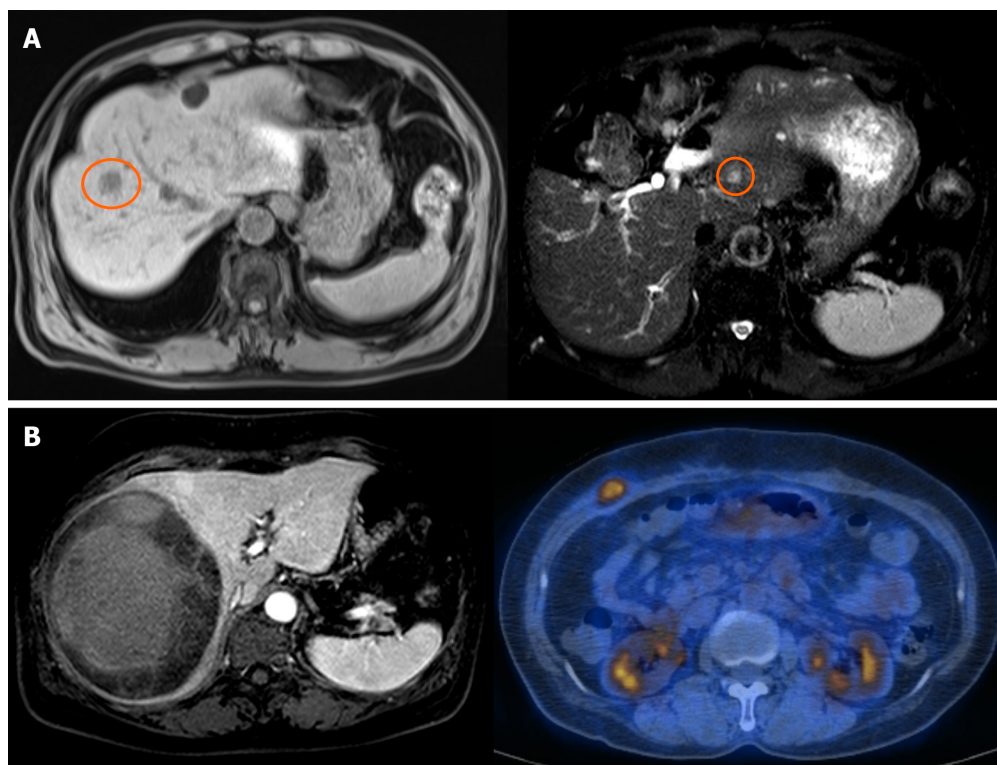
Images of a surviving patient (cases 7 and 8). A: Case 7. Left: T1 magnetic resonance imaging (MRI) of pre-operative angiosarcoma on S8 (orange circle). Right: T2 MRI of recurrence on S2 five years after central hepatectomy; B: Case 8. Left: MRI of pre-operative sarcoma. An 11.5 cm circumscribed mass with hemorrhage on the Rt. lobe. Right: Positron emission tomography-computed tomography of the recurrent mass. Focal fluoro-deoxyglucose uptake at the Rt. anterior abdominal wall.
